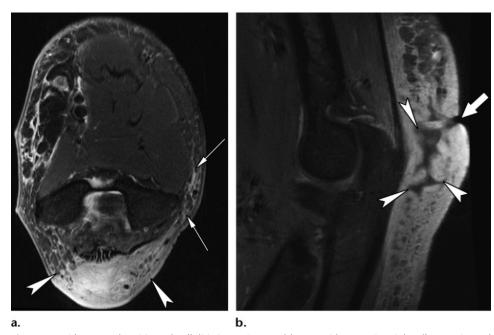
Olecranon bursitis and cellulitis in a 52-year-old man with posterior right elbow pain and swelling with fluid draining from an open skin ulcer. (a) Axial fat-saturated T2-weighted MR image of the elbow shows a localized olecranon bursal fluid collection (arrowheads) with tracking subcutaneous soft-tissue edema (arrows) about the collection. (b) Sagittal T1-weighted fat-suppressed postcontrast MR image shows thick irregular peripheral rim enhancement (arrowheads) around the bursa, consistent with bursitis. There is a sinus tract (arrow) extending from the bursa to the skin surface, with fluid drainage seen clinically. The presence of drainage and communication to the skin surface suggests that this is an infected bursa. Enhancement and edema within the subcutaneous tissues about the elbow are consistent with regional cellulitis.
